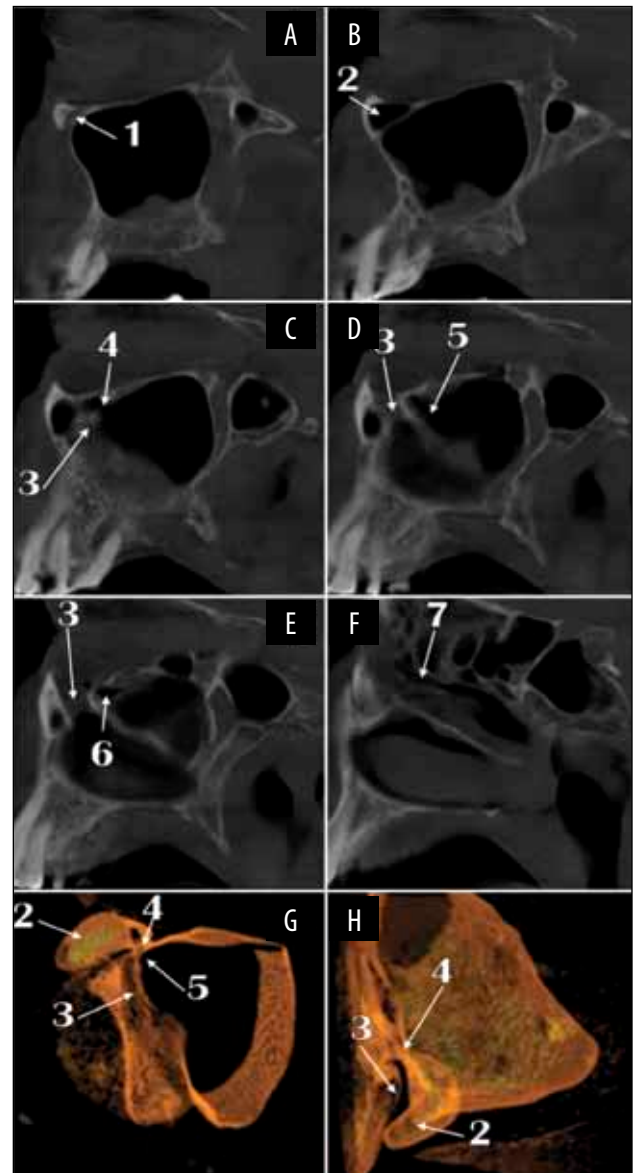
Cone Beam CT, sagittal multiplanar reconstructions, in a lateral-to-medial sequence (A-E), on the right side. The air spaces on that side are presented in a three-dimensional volume rendering (F), viewed postero-infero-laterally. 1. right infraorbital canal; 2. right infraorbital maxillary air cell (rIMAC); 3. narrow passage of drainage of the rIMAC; 4. maxillary infundibulum; 5. ostium of maxillary sinus; 6. ethmoidal infundibulum.
